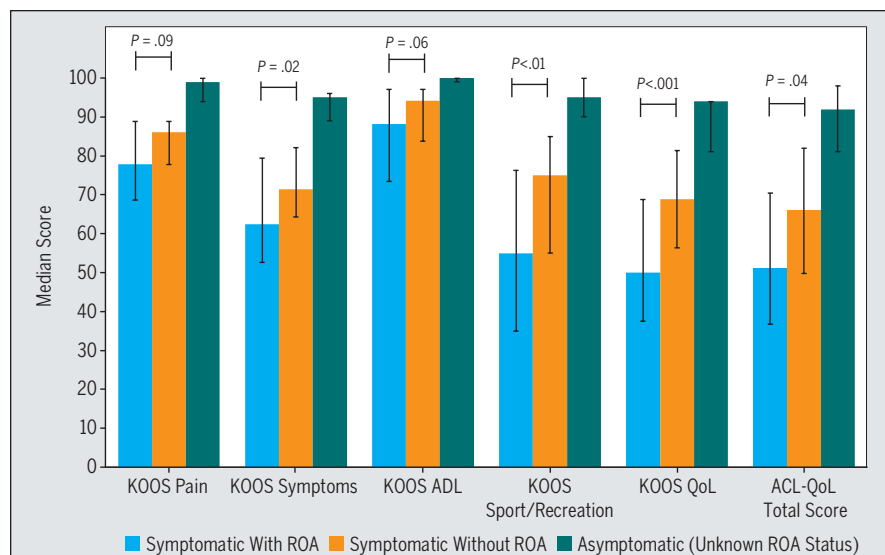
Comparison of KOOS subscale scores and total ACL-QoL scores in symptomatic people after ACL reconstruction (with and without ROA) and asymptomatic participants. All outcomes were reported as medians, and error bars represent interquartile ranges. A score of 100 represents the best possible score for each outcome. P values were obtained using Mann-Whitney U tests and are reported for symptomatic with ROA (blue) versus symptomatic without ROA (orange). Abbreviations: ACL, anterior cruciate ligament; ACL-QoL, Anterior Cruciate Ligament Quality of Life questionnaire; ADL, activities of daily living; KOOS, Knee injury and Osteoarthritis Outcome Score; QoL, quality of life; ROA, radiographic osteoarthritis.
